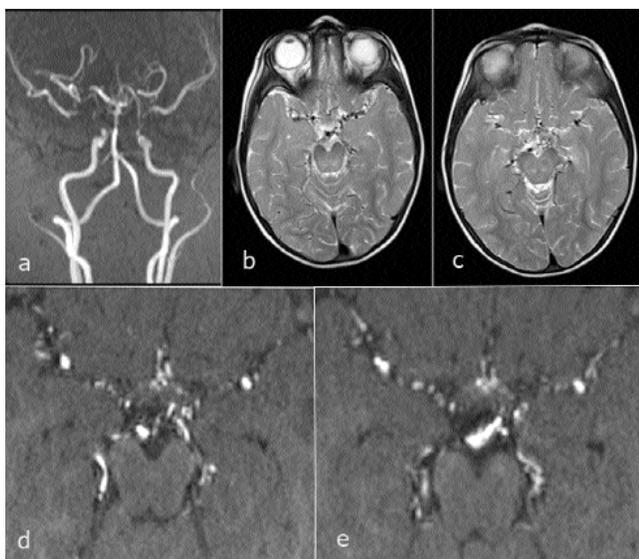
Frontal projection 3D TOF MRA image (a) shows total occlusion of the right supraclinoid internal carotid artery (ICA), excessive shrinkage in the left ICA and basilar artery and filling of the bilateral middle cerebral artery (MCA), anterior cerebral artery (ACA) and posterior cerebral arteries (PCA) via collaterals. The axial T2-weighted MR images (b, c) and source images of 3D TOF MRA (d, e) show collaterals around circle of willis, in the ambient cisterns and sylvian valleys.
